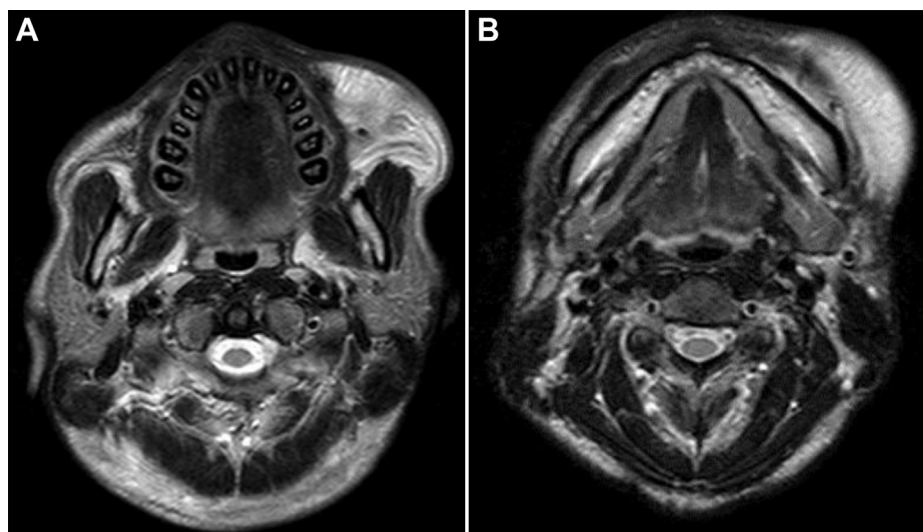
T2-weighted MRI image (horizontal plane). (A, B) A markedly high signal is shown in the left buccal region.
